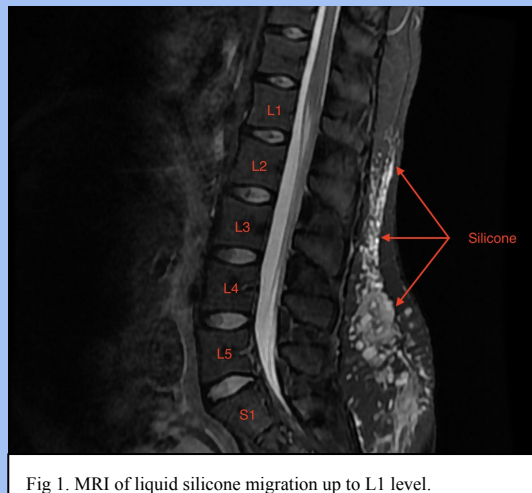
MRI of liquid silicone migration up to L1 level.
